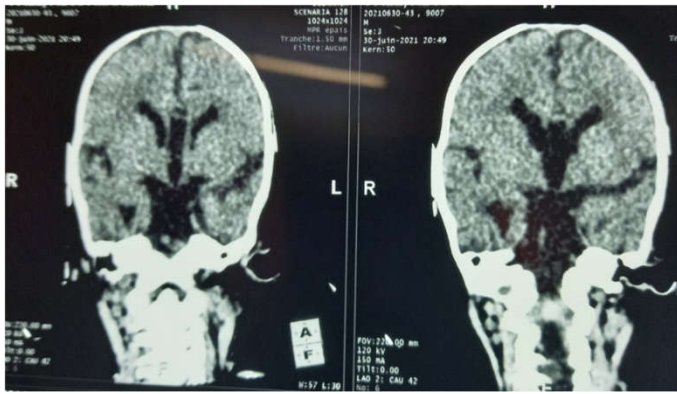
CT scan of the parenchymal window, objective coronal slices:
